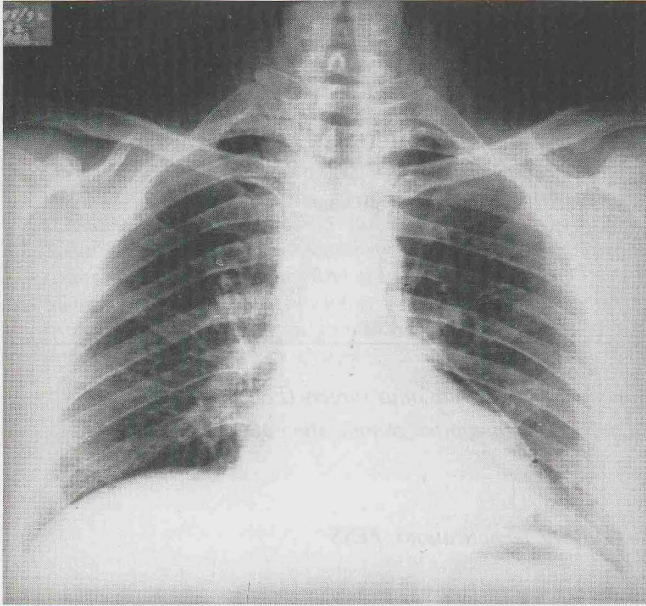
Post-operative chest X-ray showing mediastinal emphysema.
